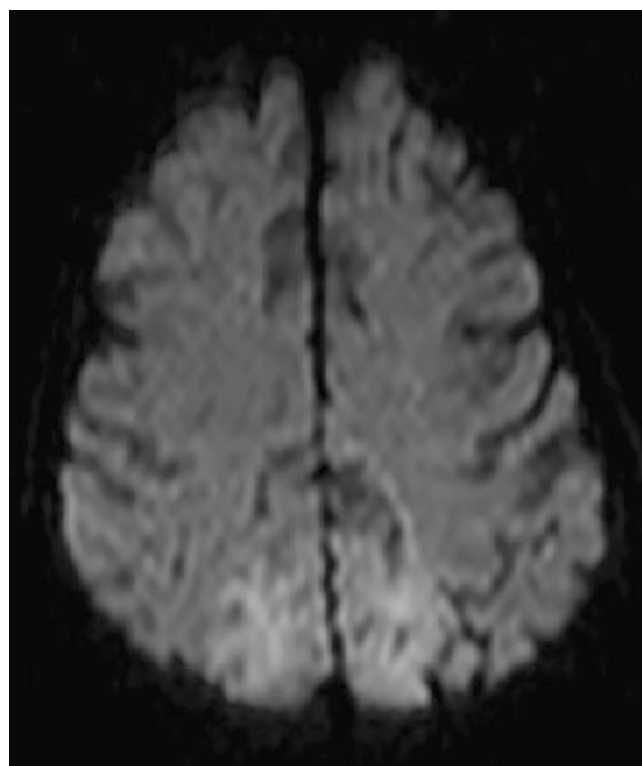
Diffusion-weighted imaging (DWI) – increased signal indicating cytotoxic edema in bilateral parasagittal parietal lobes
